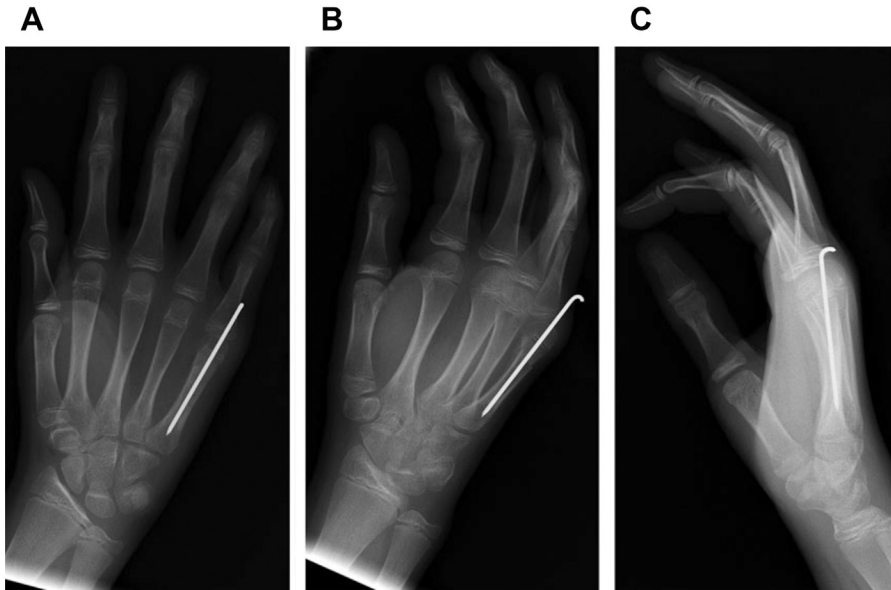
Metacarpal neck fracture. Metacarpal neck fractures are stabilized with a single pin across the physis as long as there is no rotational deformity. (A–C) Posteroanterior, oblique, and lateral radiographs, respectively, of the pin configuration. (From Cassel S, Shah AS. Metacarpal Fractures. In Scott H. Kozin, Joshua Abzug, Dan A. Zlotolow, Editors. *The Pediatric Upper Extremity*. Springer, 2014. p. 982-1003; with permission.)
